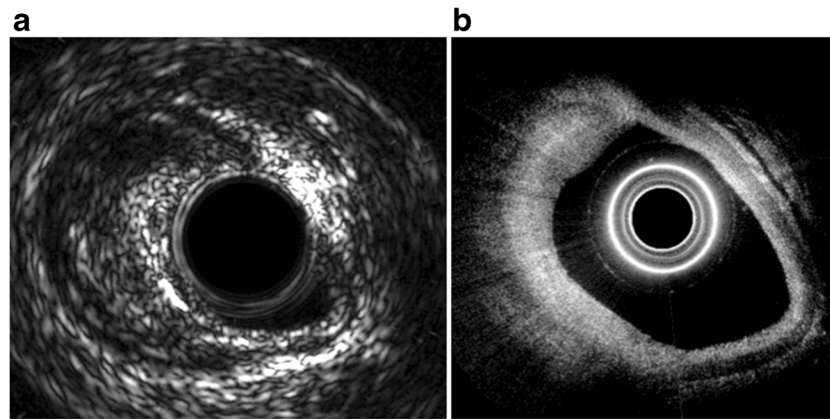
a demonstrates intravascular ultrasound of the 1st diagonal artery of a patient with diabetes (cadaveric). b demonstrates optical coherence tomography of the same vessel. Note the different tissue characterization provided by the two techniques, with superior contrast, spatial resolution
